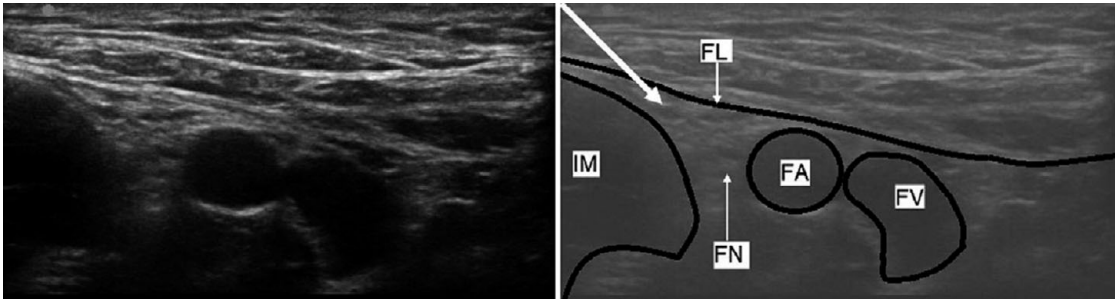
Ultrasound appearance of the femoral canal, showing the fascia lata (FL), iliacus muscle (IM), femoral nerve (FN), femoral artery (FA) and femoral vein (FV).
